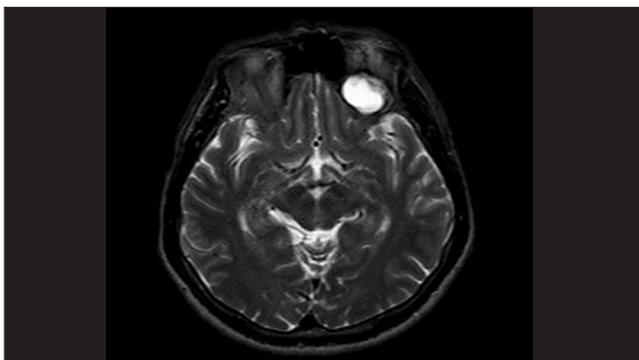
Axial MR imaging demonstrating that the lesion is smaller after the operation
